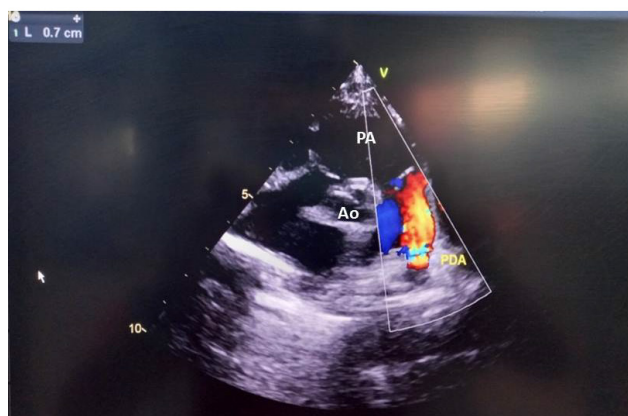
Short axis echocardiography view. The image shows a PDA with a diameter of 0.7 cm and a left-to-right shunt. PA pulmonary artery, Ao aortic valve.
